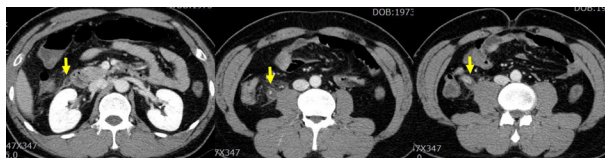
The appendiceal tip with inflammation which shown at unusually higher site on CT.
